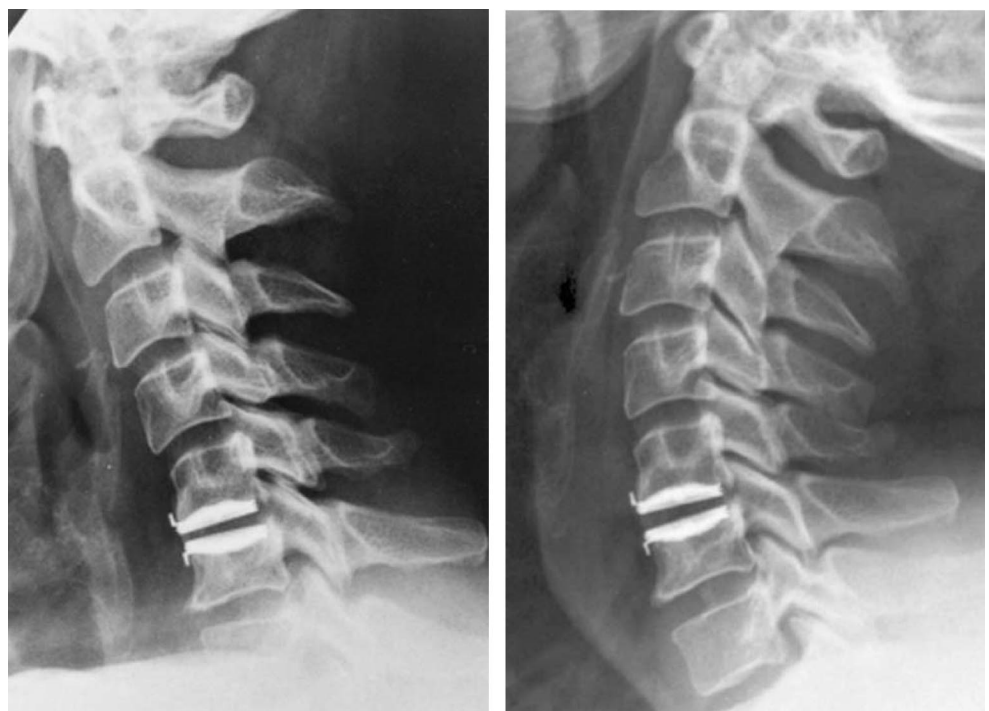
Flexion (right) and extension (left) radiographs show the angulation achieved by the implanted FSU.
